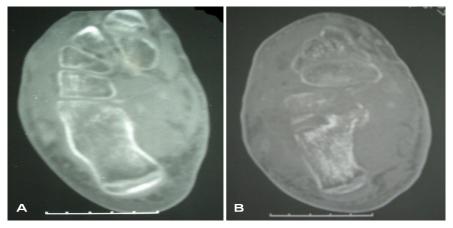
Axial CT of the left foot in soft-tissue (A) and bone (B) windows: the importance of soft tissue invasion and osteolysis.
